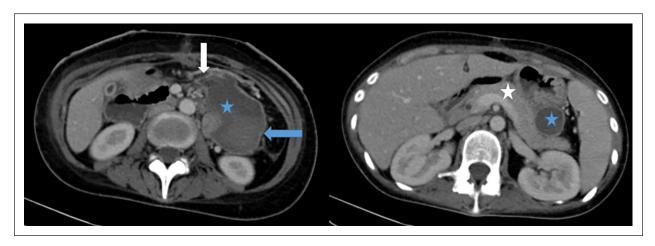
Axial computed tomography scan images in arterial phase show acute necrotizing pancreatitis involving only the peripancreatic tissues CT scan images in arterial phase showing the enhancement of the entire pancreatic parenchyma (white star) associated with heterogeneous peripancreatic collections (blue stars), fully encapsulated, containing area of fat (white arrow), fluid density, and areas with greater attenuation (blue arrow) compatible with walled-off necrosis.
